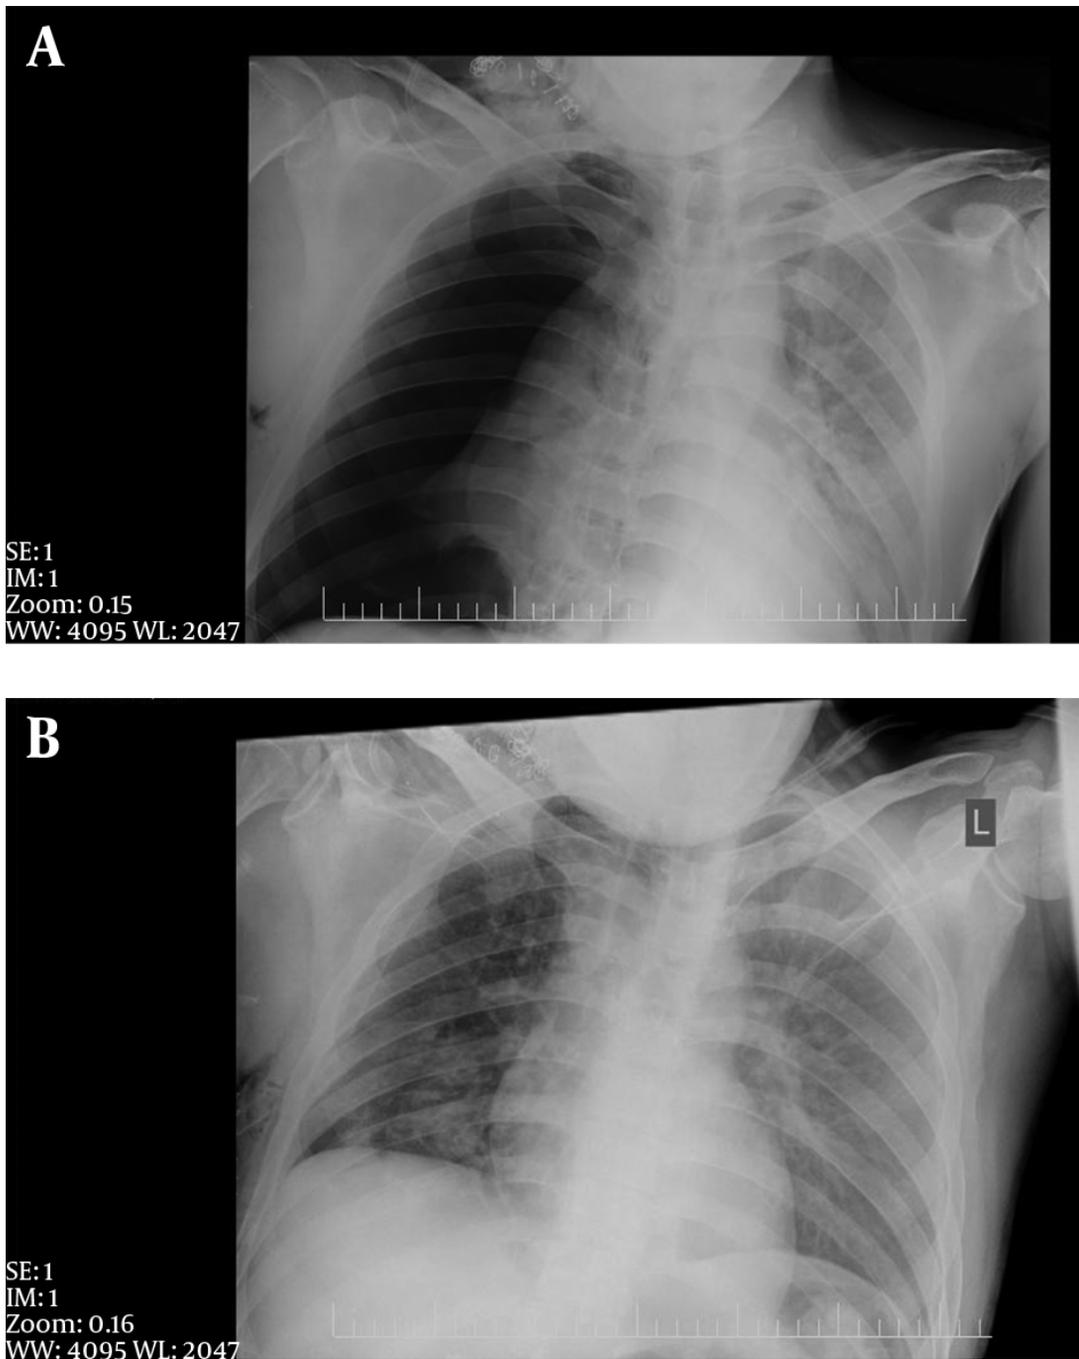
Chest X - ray Radiographs
